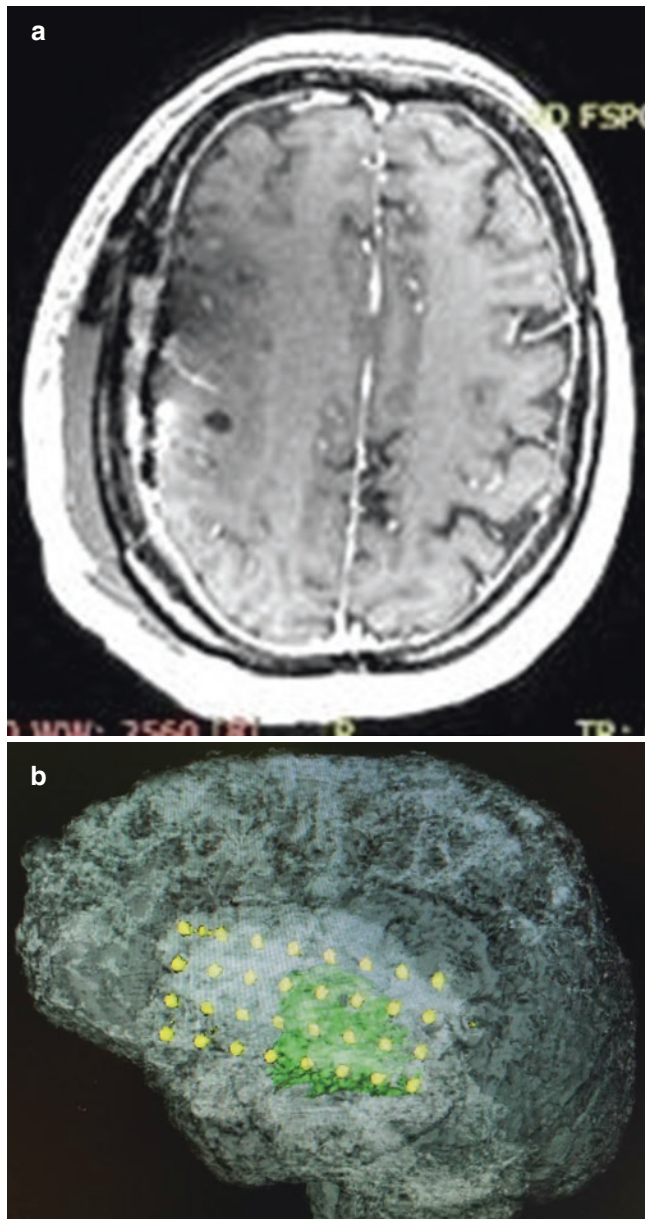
(a, b) Axial MRI image and three-dimensional reconstruction of postimplantation MRI demonstrating the exact anatomic location of each of the previously implanted subdural grids and the underlying pathology (glioma)
